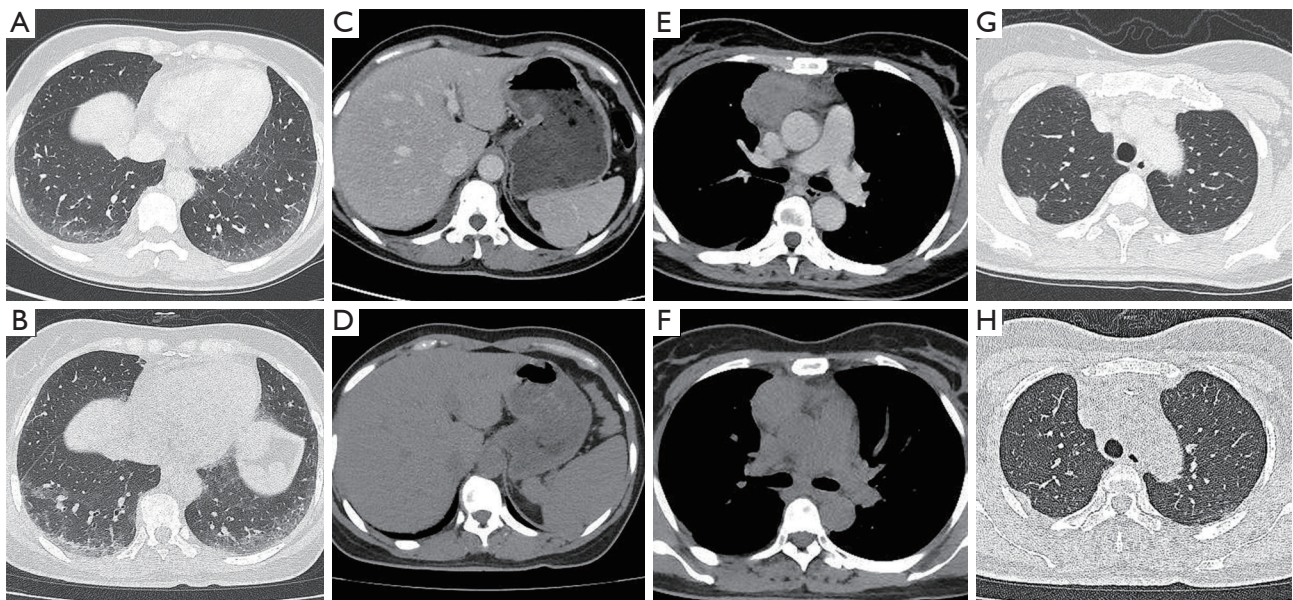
CT changes on admission (the upper panels) and 10 days after pembrolizumab administration (the lower panels). (A) A little subpleural inflammation on admission. (B) Progressive interstitial inflammation 10 days after pembrolizumab administration. (C) Normal-sized spleen. (D) Splenomegaly. (E,F) Chest CT shows smaller antero-superior mediastinal mass 10 days after pembrolizumab administration than on admission. (G,H) The node on right costal pleura was smaller 10 days after pembrolizumab administration than on admission. CT, computed tomography.
